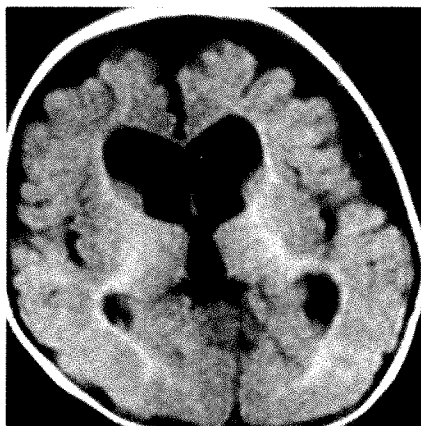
Axial MR image (SE 550/20) in an 8-month-old girl shows dilated third and lateral ventricles with widening of frontal sulci and interhemispheric fissure.
